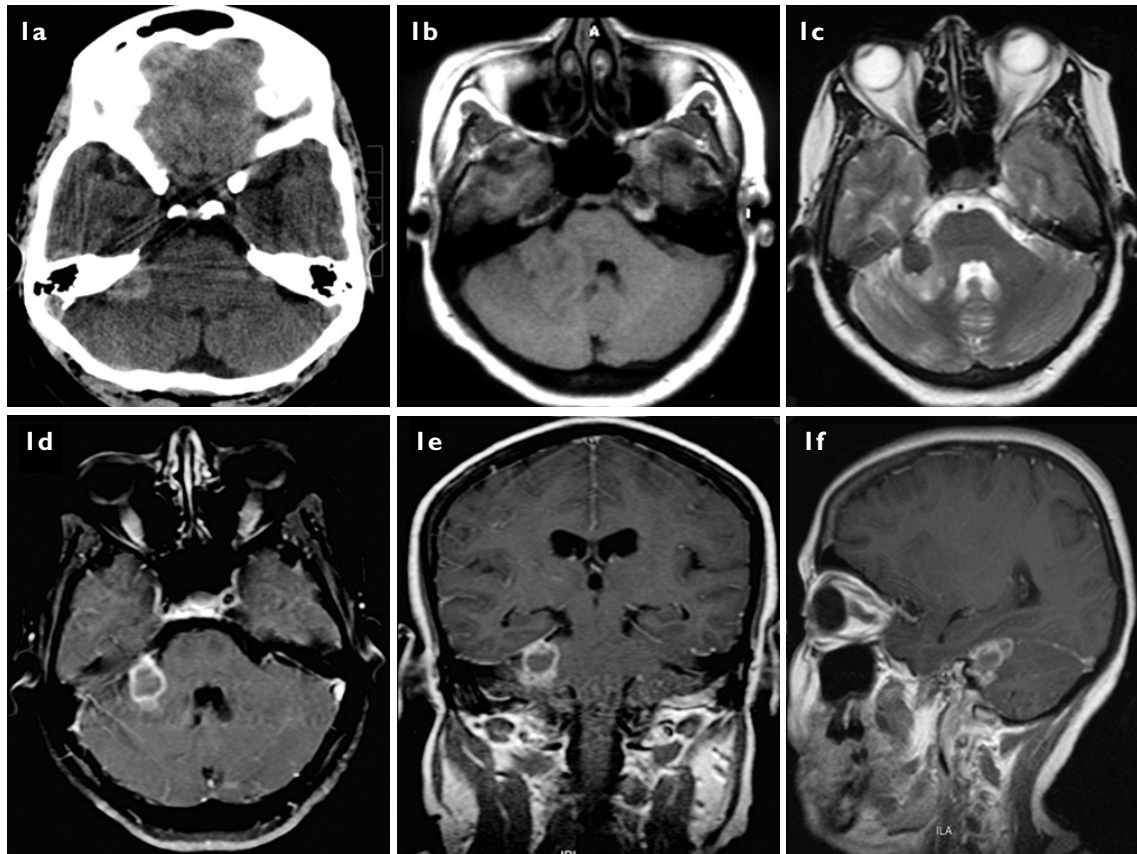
(a) Axial CT image of the brain shows a round hyperdense lesion in the flocculus of the right cerebellar hemisphere. (b) Axial T1-W MR image of the posterior fossa shows an intra-axial isointense lesion with a mild hypointense peripheral rim in the flocculus of the right cerebellar hemisphere. (c) Axial T2-W MR image shows that the lesion appears profoundly hypointense with surrounding moderate perilesional oedema. (d) Contrast-enhanced axial T1-W MR image shows a ring-enhancing lesion in the right cerebellopontine angle region. (e) Contrast-enhanced coronal T1-W MR image shows the irregular lobulated margin of the ring-enhancing lesion with minimal enhancement of the adjacent tentorium. (f) Contrast-enhanced sagittal T1-W MR image shows a ring-enhancing lesion with an irregular lobulated margin.
